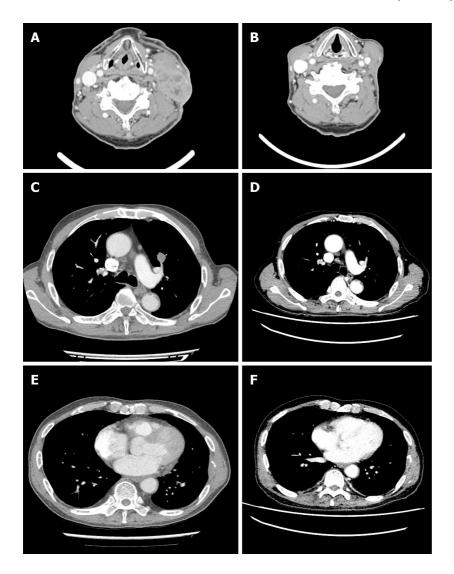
After 3 cycles of pembrolizumab, contrast-enhanced neck and chest computed tomography and evaluation after 4th chemotherapy. A, C, E: Evaluation after 4th chemotherapy; B, D, and F: After 3 cycles of pembrolizumab, contrast-enhanced neck and chest computed tomography shows the markedly decreased size of metastatic lymphadenopathy on both cervical level II to V, enhanced nodule in anterior segment of left upper lobe, and mass in left 7th rib compared with response evaluation after 4th chemotherapy.
